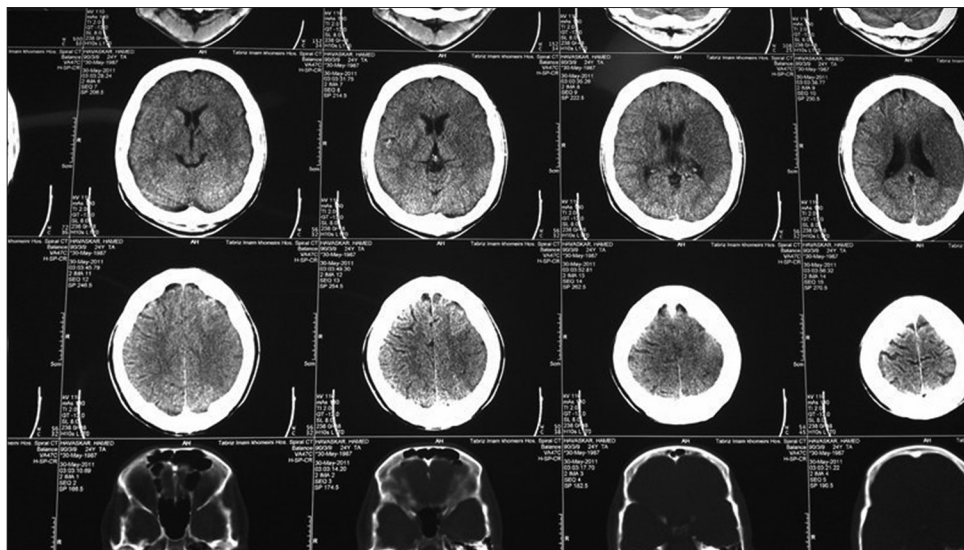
Patient's computed tomography scan in admission
